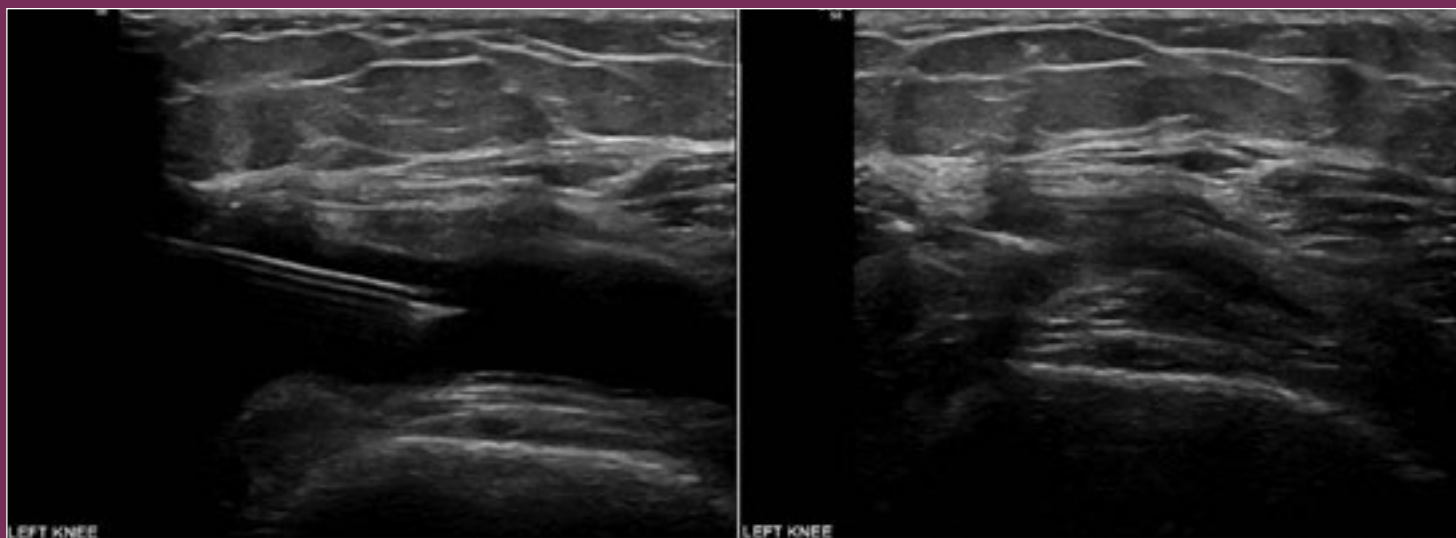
Ultrasound left knee – moderate knee effusion before and after knee aspiration.
